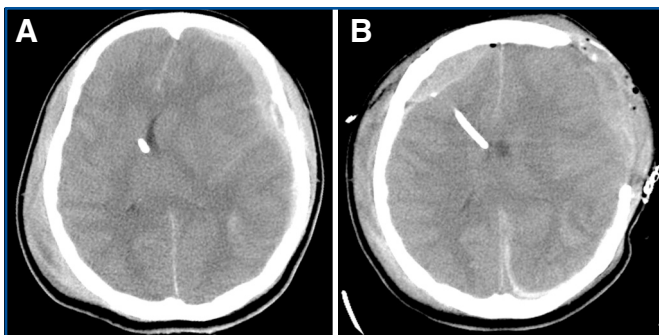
CT scan showing a 14-year-old girl with a left subdural hematoma (A) who developed a delayed right epidural hematoma at the EVD site after a left craniotomy (B) and required surgical evacuation.
